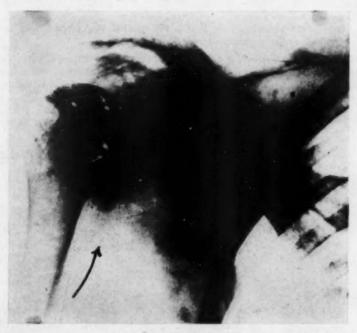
Roentgenogram of the right shoulder, taken two months before death. An extensive, rapidly growing osteogenic chondrosarcoma may be noted springing from the anterior surface of the scapula and the glenoid process.
